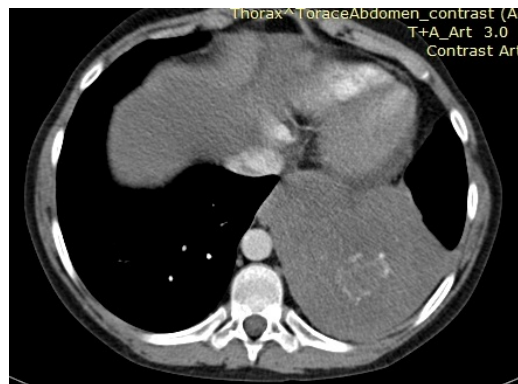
CT chest and abdomen February 2018*
